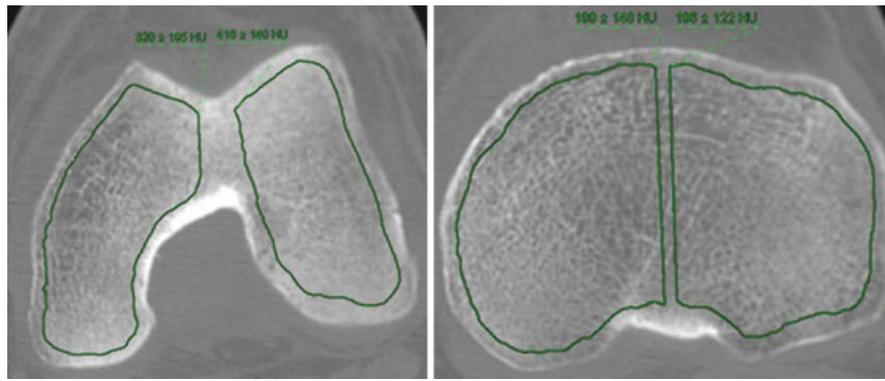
Computed tomographic scan slices demonstrating the area defined for trabecular bone density measurement.
